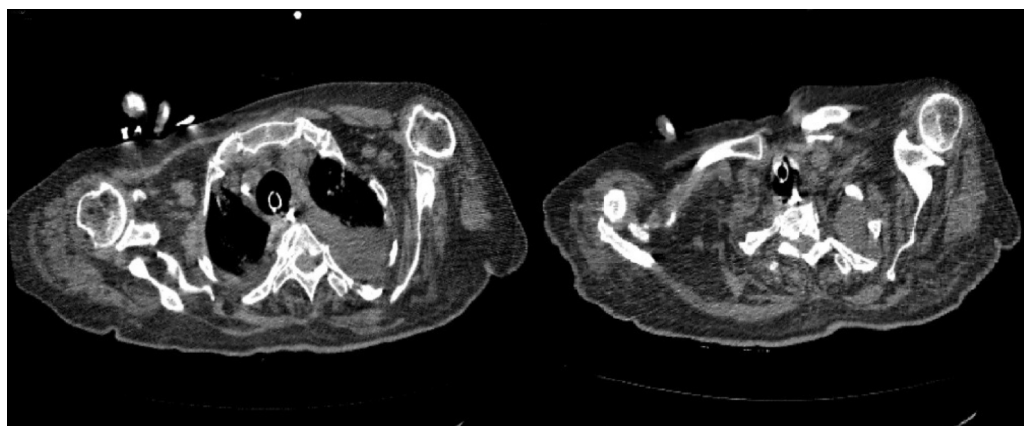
Large joint view between the posterior wall of the trachea and esophagus on thorax CT.
